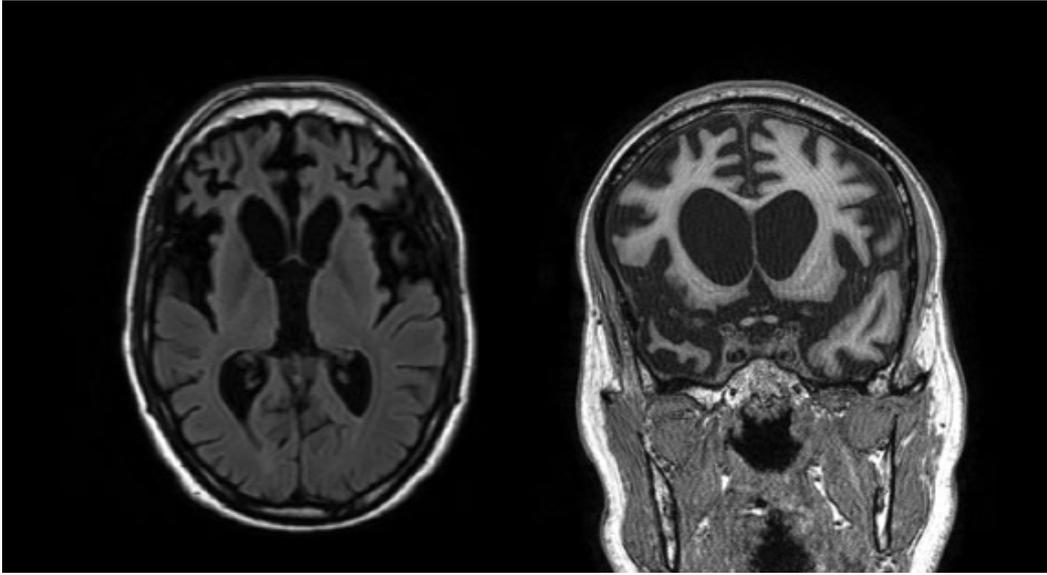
According to cranial MRI of 38 years old male bvFTD patient, advanced grade atrophy is noted in anterior fronto insular, temporal cortex and subcortical caudate nucleus.⁽³²⁾
